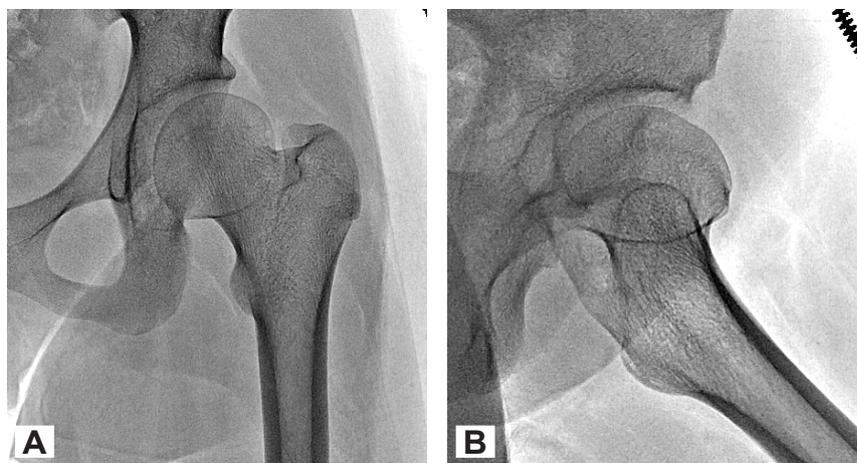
X-ray left hip in 7 years after treatment: A – at plane radiograph shortness of femoral neck and enlargement of femoral head with ideal sphericity; B – frog leg position sphericity alterations within 2 mm
